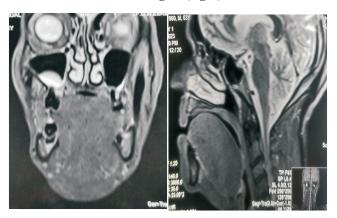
Coronal and sagittal sections of MR imaging revealing a hypertrophied tongue.
